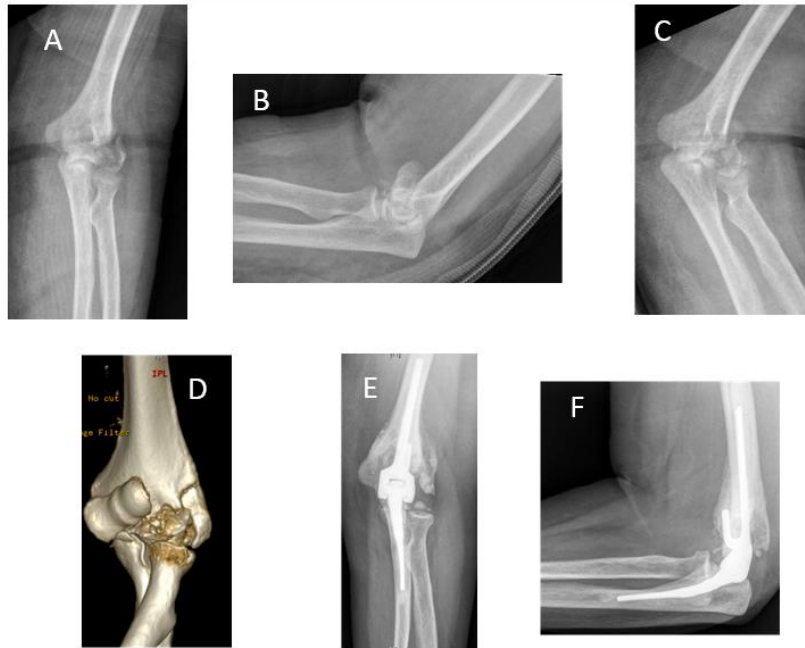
72-year-old female with a comminuted, displaced, distal humerus fracture. Due to the fracture pattern, reconstruction was deemed impossible during surgery, and therefore patient underwent total elbow arthroplasty (TEA): (A-D) preoperative views; (E-F) postoperative radiographs
